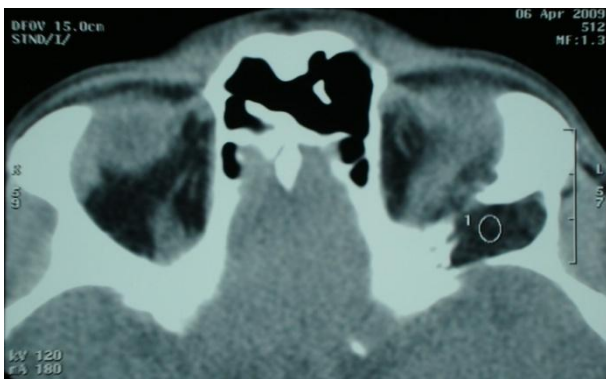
Orbital CT-scan (axial view)
